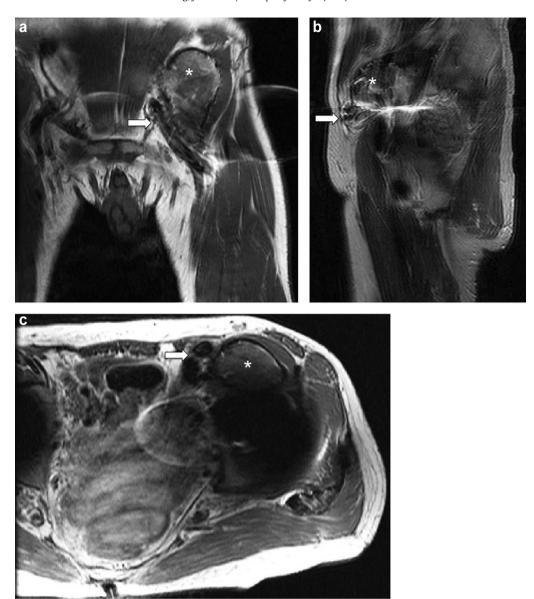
(a) Coronal, (b) sagittal, and (c) axial T1 MRI images of the left hip prior to revision demonstrated a heterogeneous mixed signal lesion within the substance of the left iliacus and iliopsoas muscle (asterisk). The lesion has a mass effect on the surrounding structures and displaces the external iliac and femoral artery (arrow).
